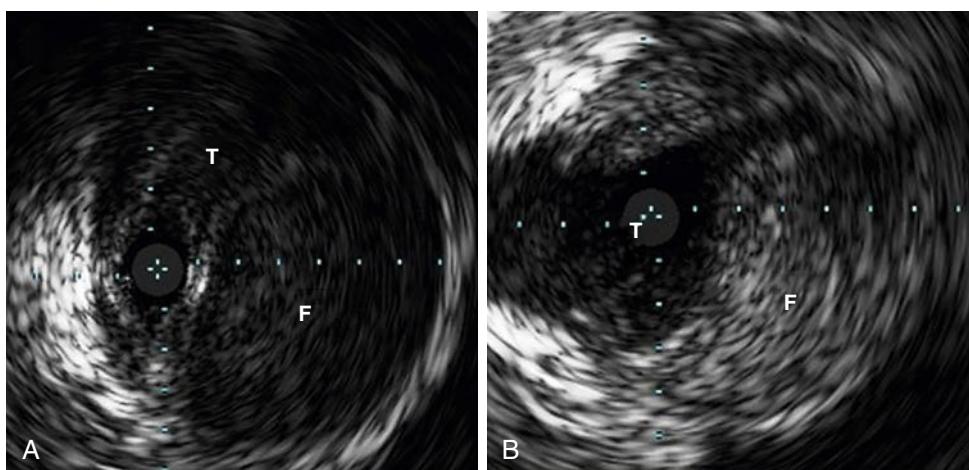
Intravascular ultrasound revealing renal artery dissection flap with compromised true lumen. (A) Proximal portion of left renal artery. (B) Distal portion of left renal artery. F, false lumen; T, true lumen. (From Watanabe Y, Aramoto H, Asano R, Furuichi S et al. Iatrogenic renal artery dissection uncommon complication during aortic endovascular repair. *JACC Cardiovasc Interv.* 2010;3(9):986–987.)
